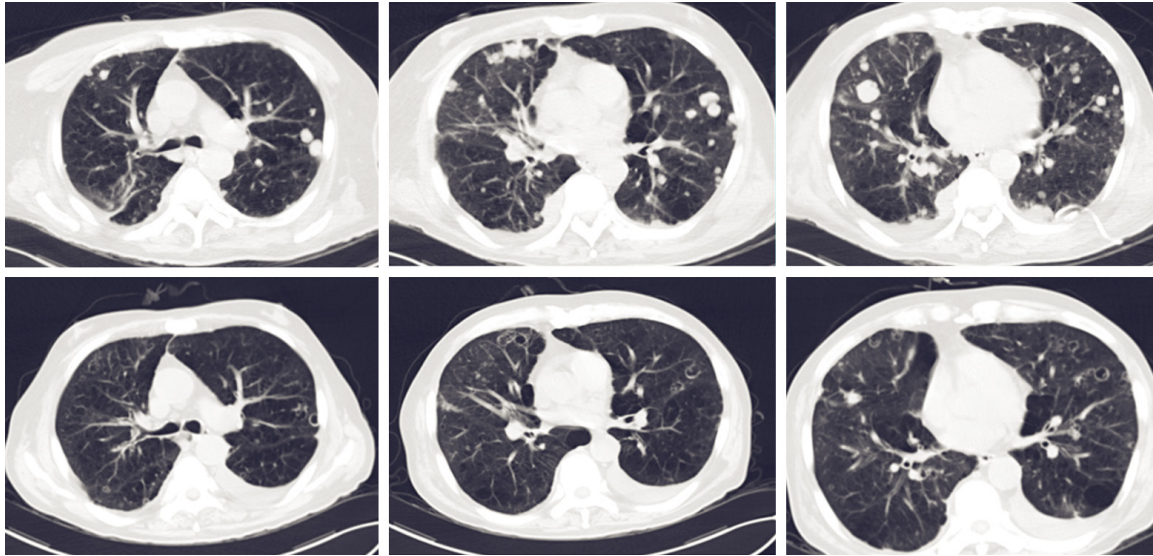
CT findings of the patient's chest before and after treatment with anlotinib. Double lung metastasis was shown before treatment, and reexamination after treatment showed that the metastatic nodules disappeared or shrank, accompanied by the formation of a cavity.
